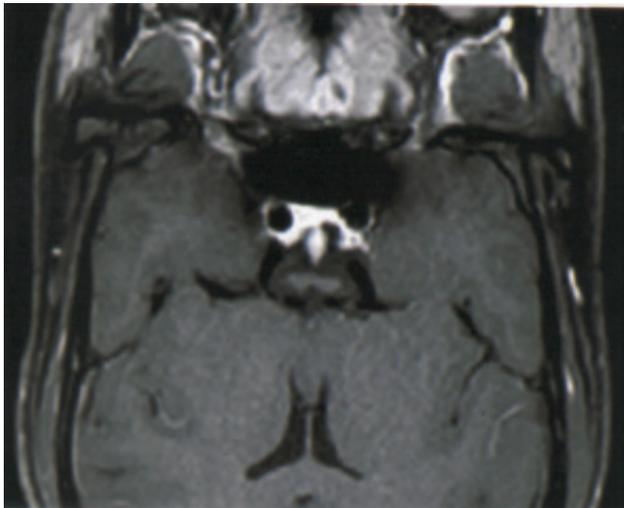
Contrast-enhanced magnetic resonance T1-weighted image, coronal section demonstrates contrast enhancement of thickened infundibulum.
